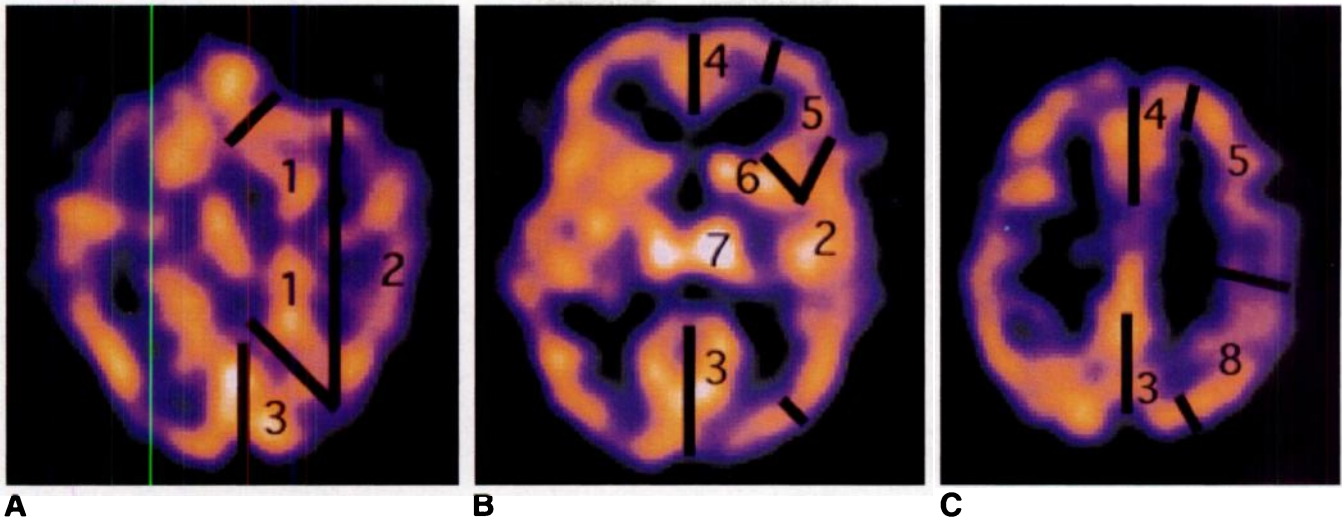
A–C, Regions of interest (ROIs) on SPECT images of a patient with chronic fatigue syndrome. Axial images at three levels show the eight ROIs used in analysis: (1) medial temporal cortex, (2) lateral temporal cortex, (3) occipital cortex, (4) medial frontal cortex, (5) lateral frontal cortex, (6) basal ganglia (including caudate nucleus and putamen), (7) thalamus, and (8) parietal cortex.
